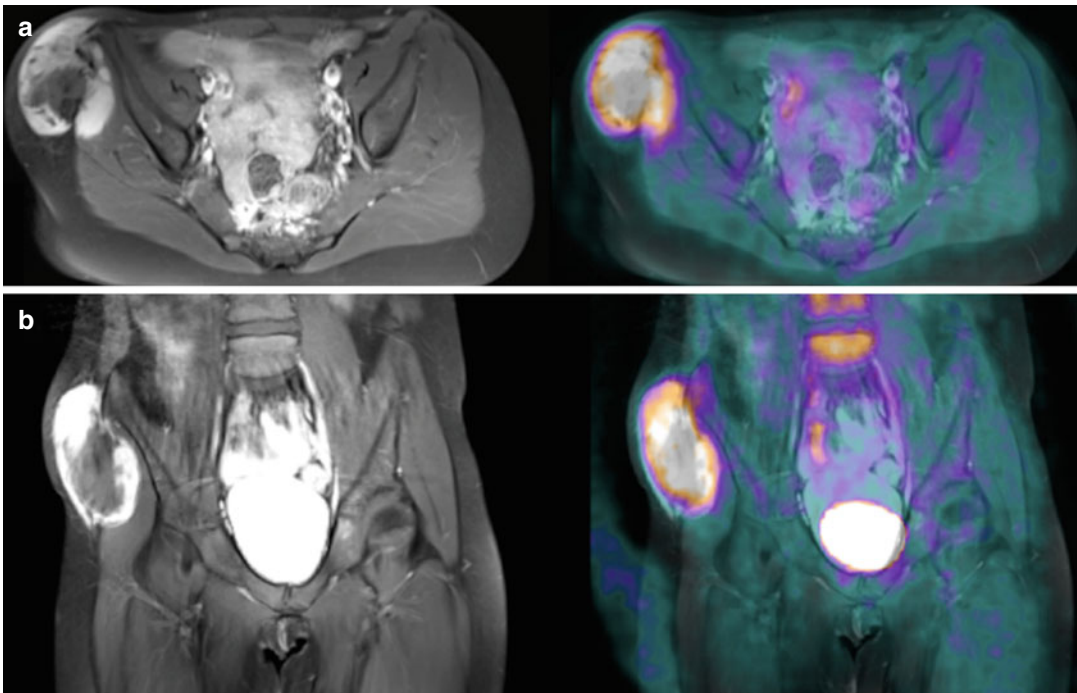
Fibromyxoid sarcoma. A 10-year-old female presented with a slowly enlarging mass on the side of her right pelvis. MRI (*left* axial (a), coronal (b)) showed a heterogeneous mass with intermediate T1 intensity arising in the gluteus medius and having areas of central necrosis. There were prominent lymph nodes in the inguinal and right pelvic wall suggesting possible metastatic
